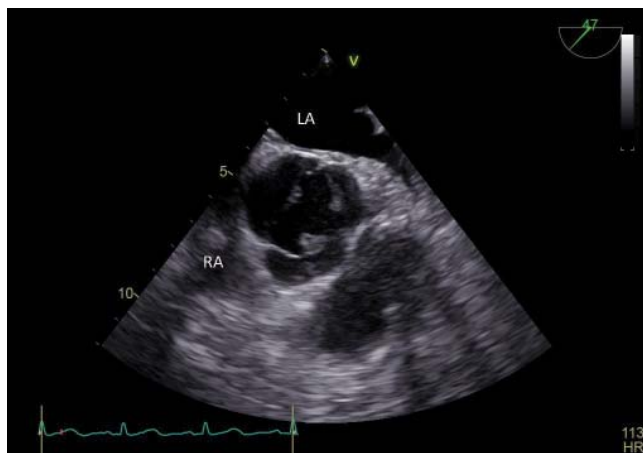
Transesophageal echocardiography – midesophageal aortic short axis view, zoom on the aortic valve- all three leaflets are involved.
